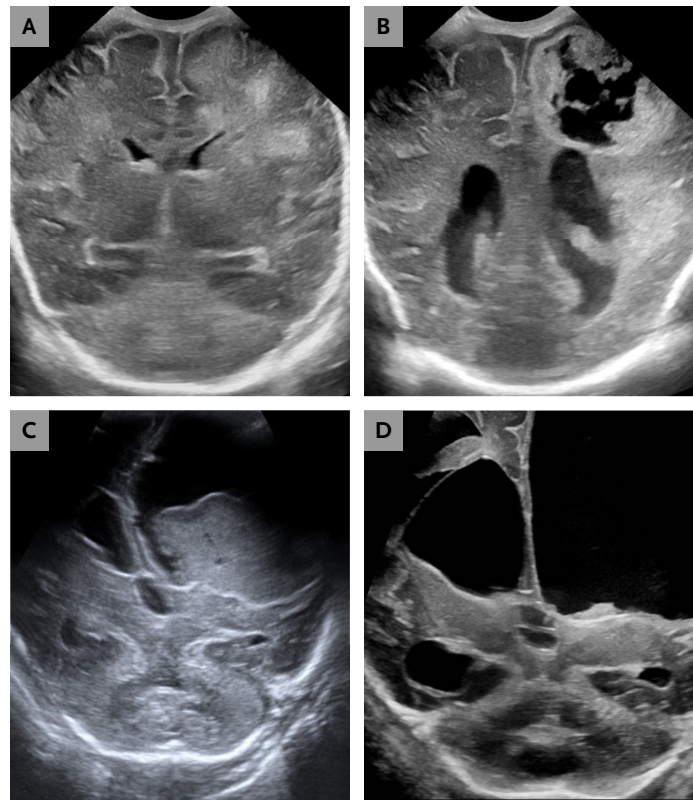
Representative Brain Ultrasound Images from an Infant with *Paenibacillus dendritiformis* Meningitis Cared for at Penn State Health Children's Hospital.
